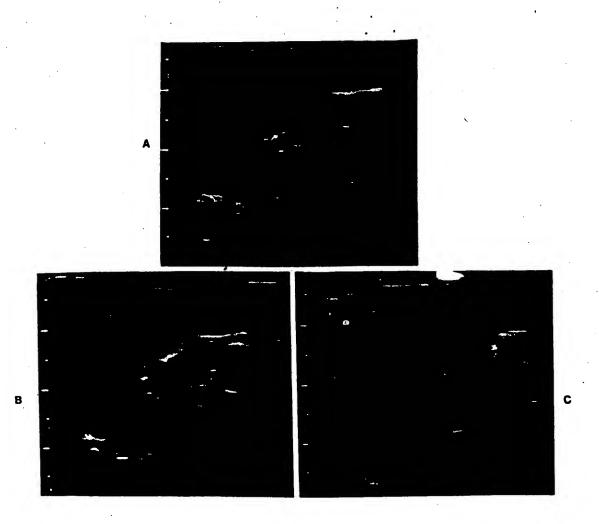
Renal cortical col r Doppler enhancement following Albunex administration. Transverse images through the renal hilum of a woodchuck kidney, A, before, and after, B, the intraven us administrati n f 0.2 ml/kg Albunex sh ws enhancement of the central renal arteries (coded in red). Tw seconds later, at a 1 wer transverse image of the kidney, C, dense c rtical color Doppler enhancement is present lasting 5 to 6 seconds.
